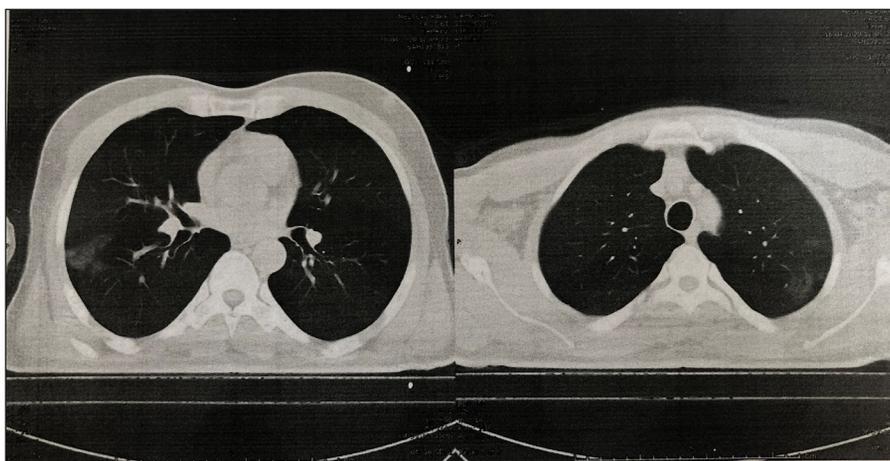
Computed tomography of the lungs with COVID-19
